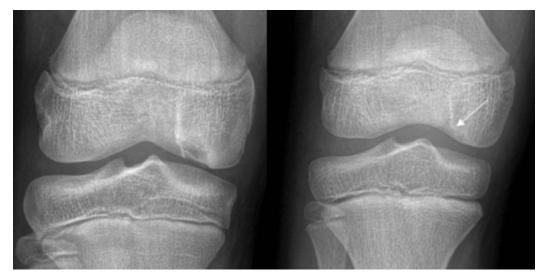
AP views of the right knee of a patient diagnosed with OCD of the medial femoral condyle at age 15 (left). Radiographs performed at age 12 (right) for a limp and heel pain show a subtle lucecny (arrow) in the area of the later diagnosed OCD lesion.
